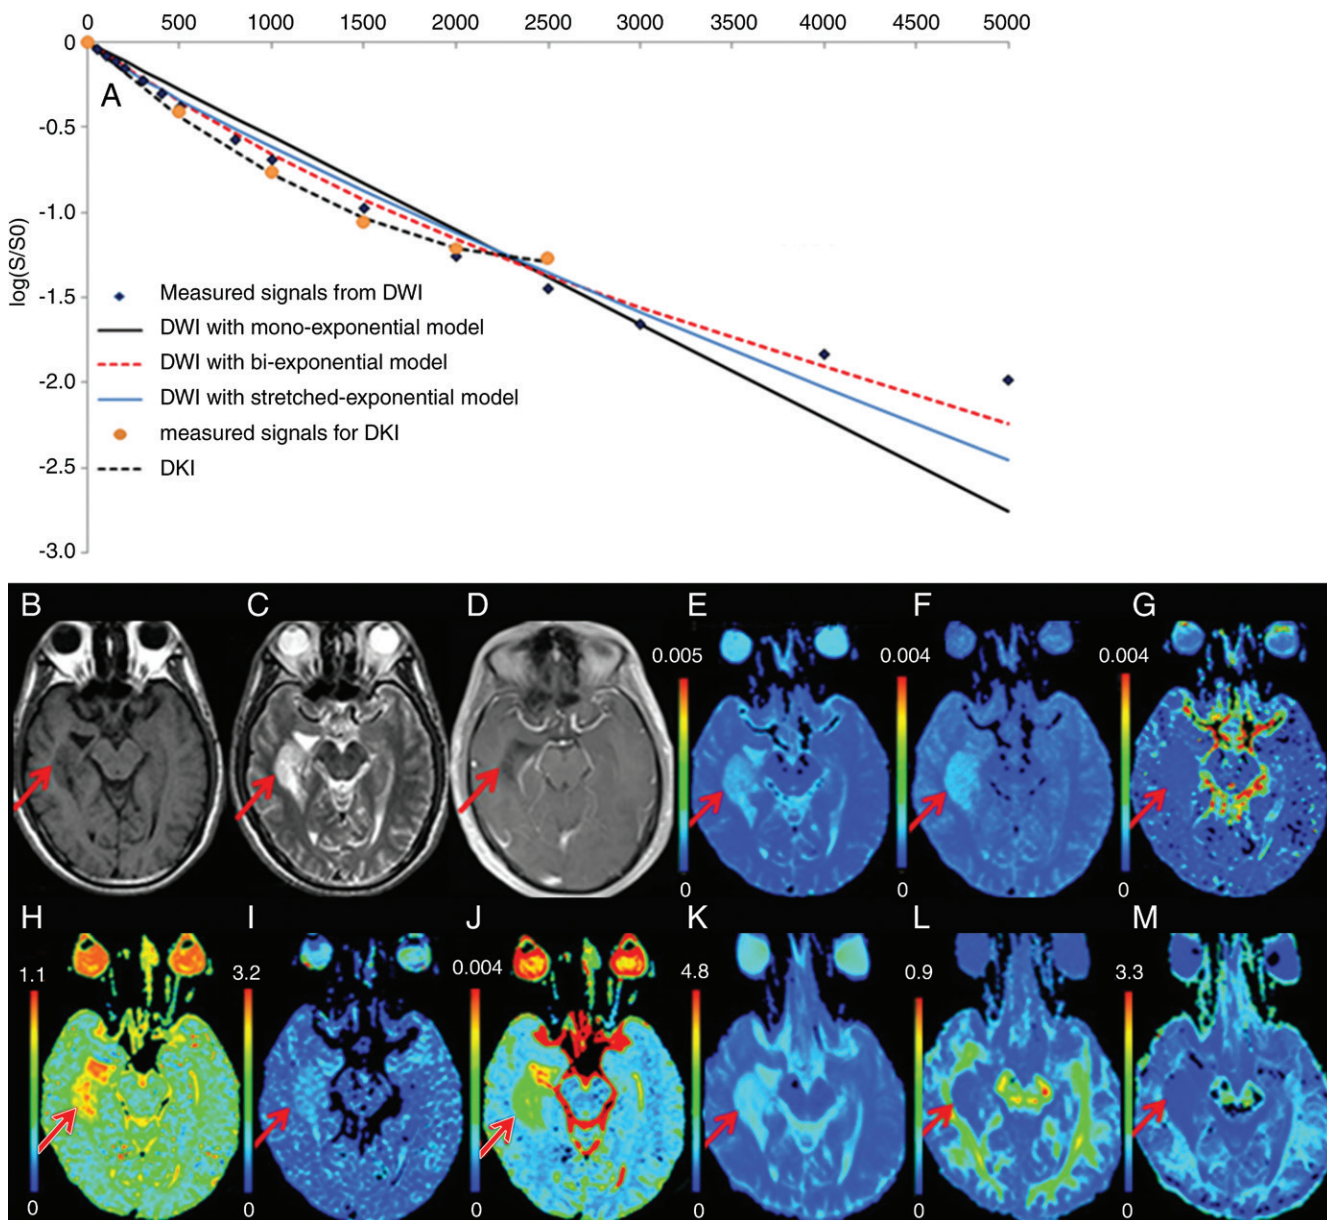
Low-grade astrocytoma (WHO grade II) in the right temporal lobe (arrows) in a 43-year-old woman. *A*, The curves of different fits were derived from DWI by using monoexponential, biexponential, and stretched exponential models and DKI. *B*, T1-weighted MR image shows that the tumor is hypointense. *C*, T2-weighted MR image shows that the tumor is hyperintense. *D*, Gadolinium-based contrast-enhanced T1-weighted MR image shows that the tumor has no enhancement. In the tumor, *E*, the ADC map and, *F*, the ADC_{slow} map show increased values. *G*, The ADC_{fast} map shows decreased values. The, *H*, *f* map, *I*, α map, *J*, DDC map, and, *K*, mean diffusivity map show increased values. The, *L*, FA and, *M*, MK map show decreased values.
